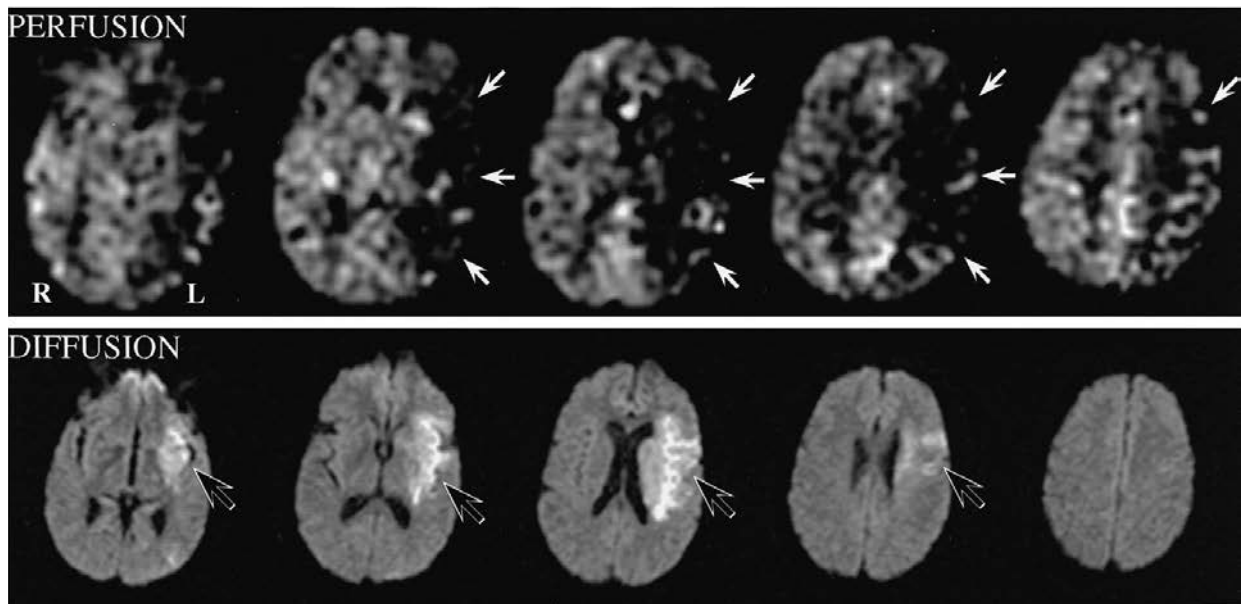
Perfusion and diffusion MRI in a patient presenting with acute right hemiparesis and aphasia. Top panel: Perfusion MRI obtained using ASL demonstrates hypoperfusion throughout the left middle cerebral artery distribution (white arrows). Bottom panel: Diffusion MRI demonstrates a somewhat smaller region of cytotoxic injury (black arrows). Images are in radiological orientation (left is on the right).
